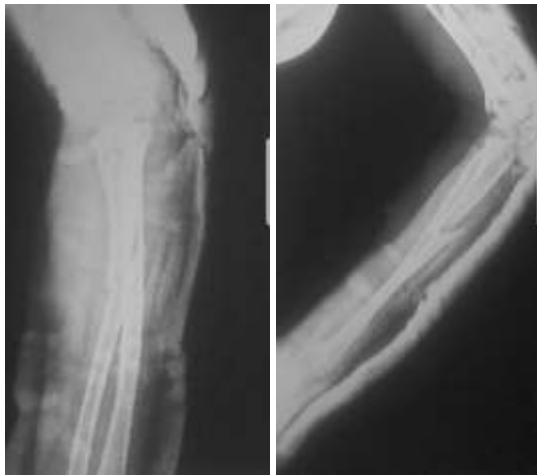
Anteroposterior and lateral radiographs of the same fracture after closed reduction and above elbow plaster application depicting acceptable reduction of the ulnar fracture and relocation of the radial head.
